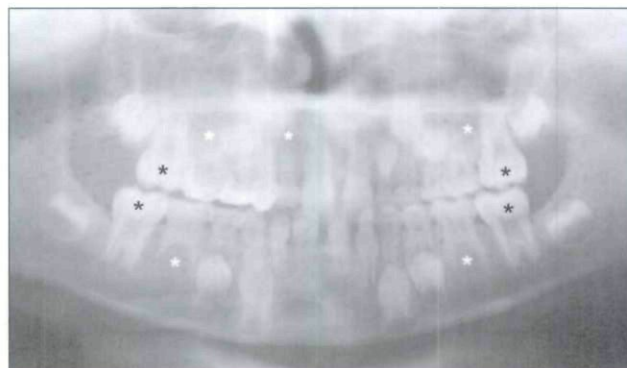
Representative panoramic radiograph of 7-year-old patient at diagnosis who received chemotherapy and 2,100 cGy. Notice hypodontia of mandibular and maxillary second premolars and right lateral incisor (light asterisks) and taurodontia (dark asterisks) of mandibular and maxillary first molars.
